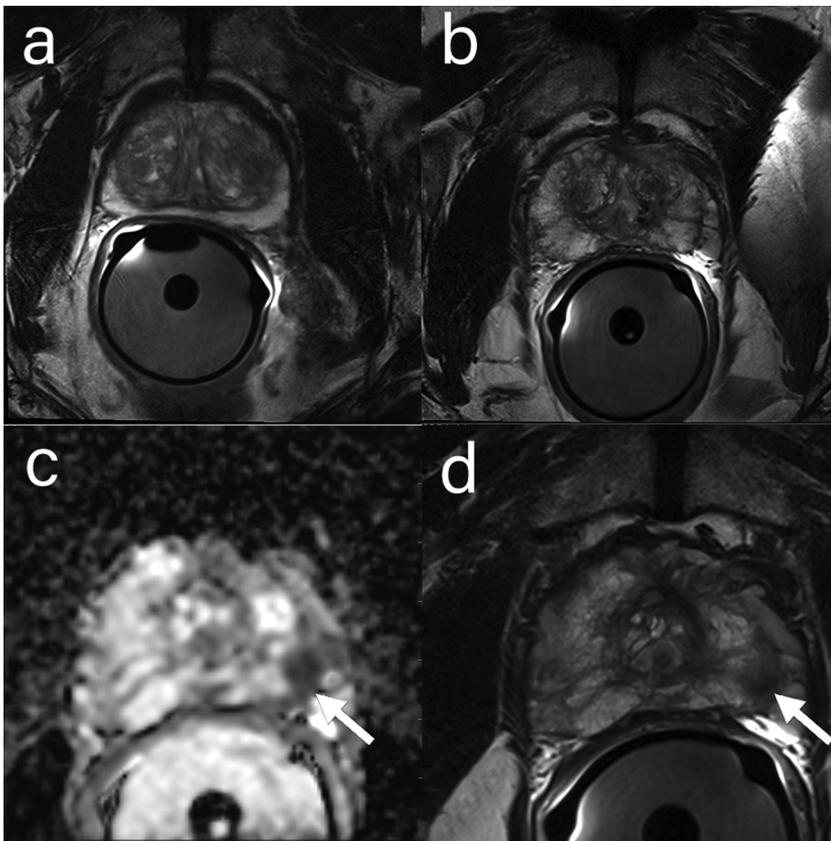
(a) Example of a patient with high PSA but also large TZ volume and no cancer (Serum PSA = 13.1 ng/ml; PSAD = 0.22 and TZPSAD 0.26 ng/ml²) (b) midglandular axial T2 section of a 55 year-old patient with serum PSA elevation and a relatively small TZ (Serum PSA 9.16 ng/ml, PSAD: 0.23 and TZPSAD: 0.45 ng/ml²). The culprit in this patient was an apical tumor (Gl. score 4 + 4) as marked by an arrow in the DWI (c) and an apical T2 slice (d).
